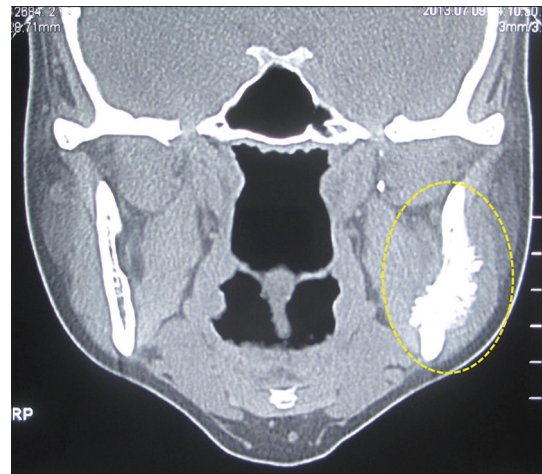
Coronal computed tomography scan showing destructive lesion on left angle of mandible extending into the ramus. Codman triangle and sunray appearance seen in the margin of the lesion
